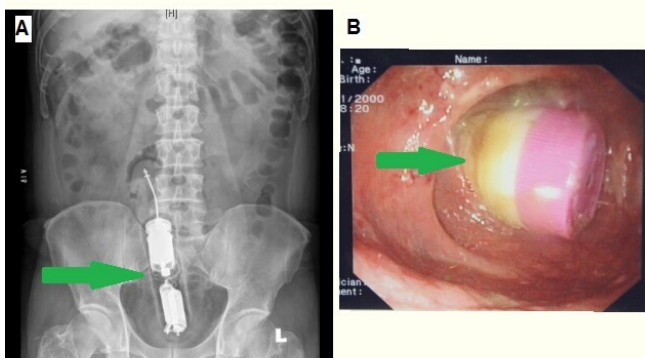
A. Abdominal radiograph showing an impacted rectal foreign body (green arrow); B. Failed colonoscopic removal of the foreign body.
